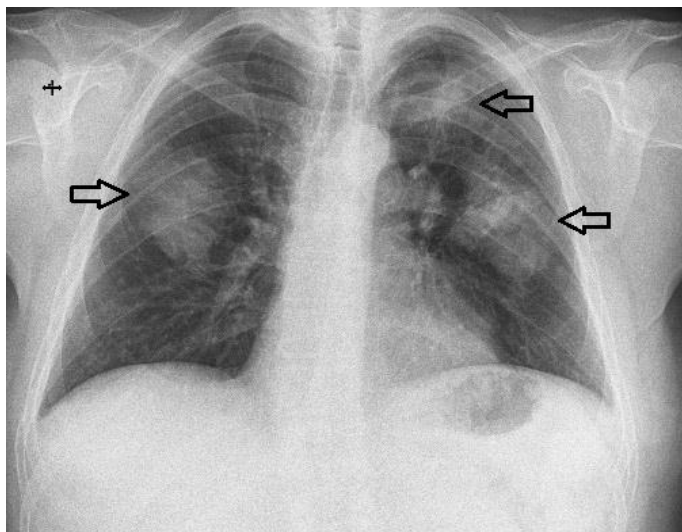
Chest X-ray PA - Multiple nodular opacities of medium intensity and variable sizes, poorly defined, located in both lung fields (black arrows)
